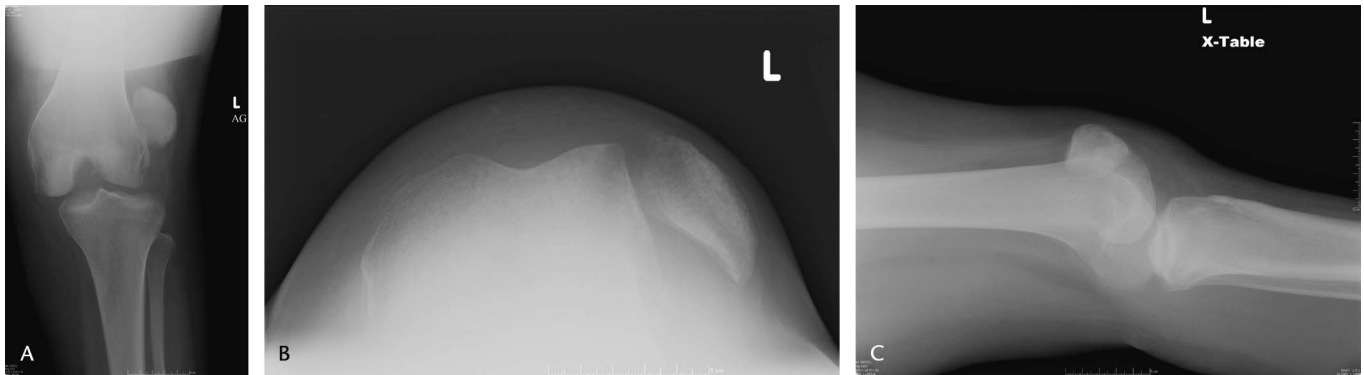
A, Anteroposterior radiograph 3 months after injury. B, Patellar view 3 months after injury. C, Lateral view 3 months after injury.
